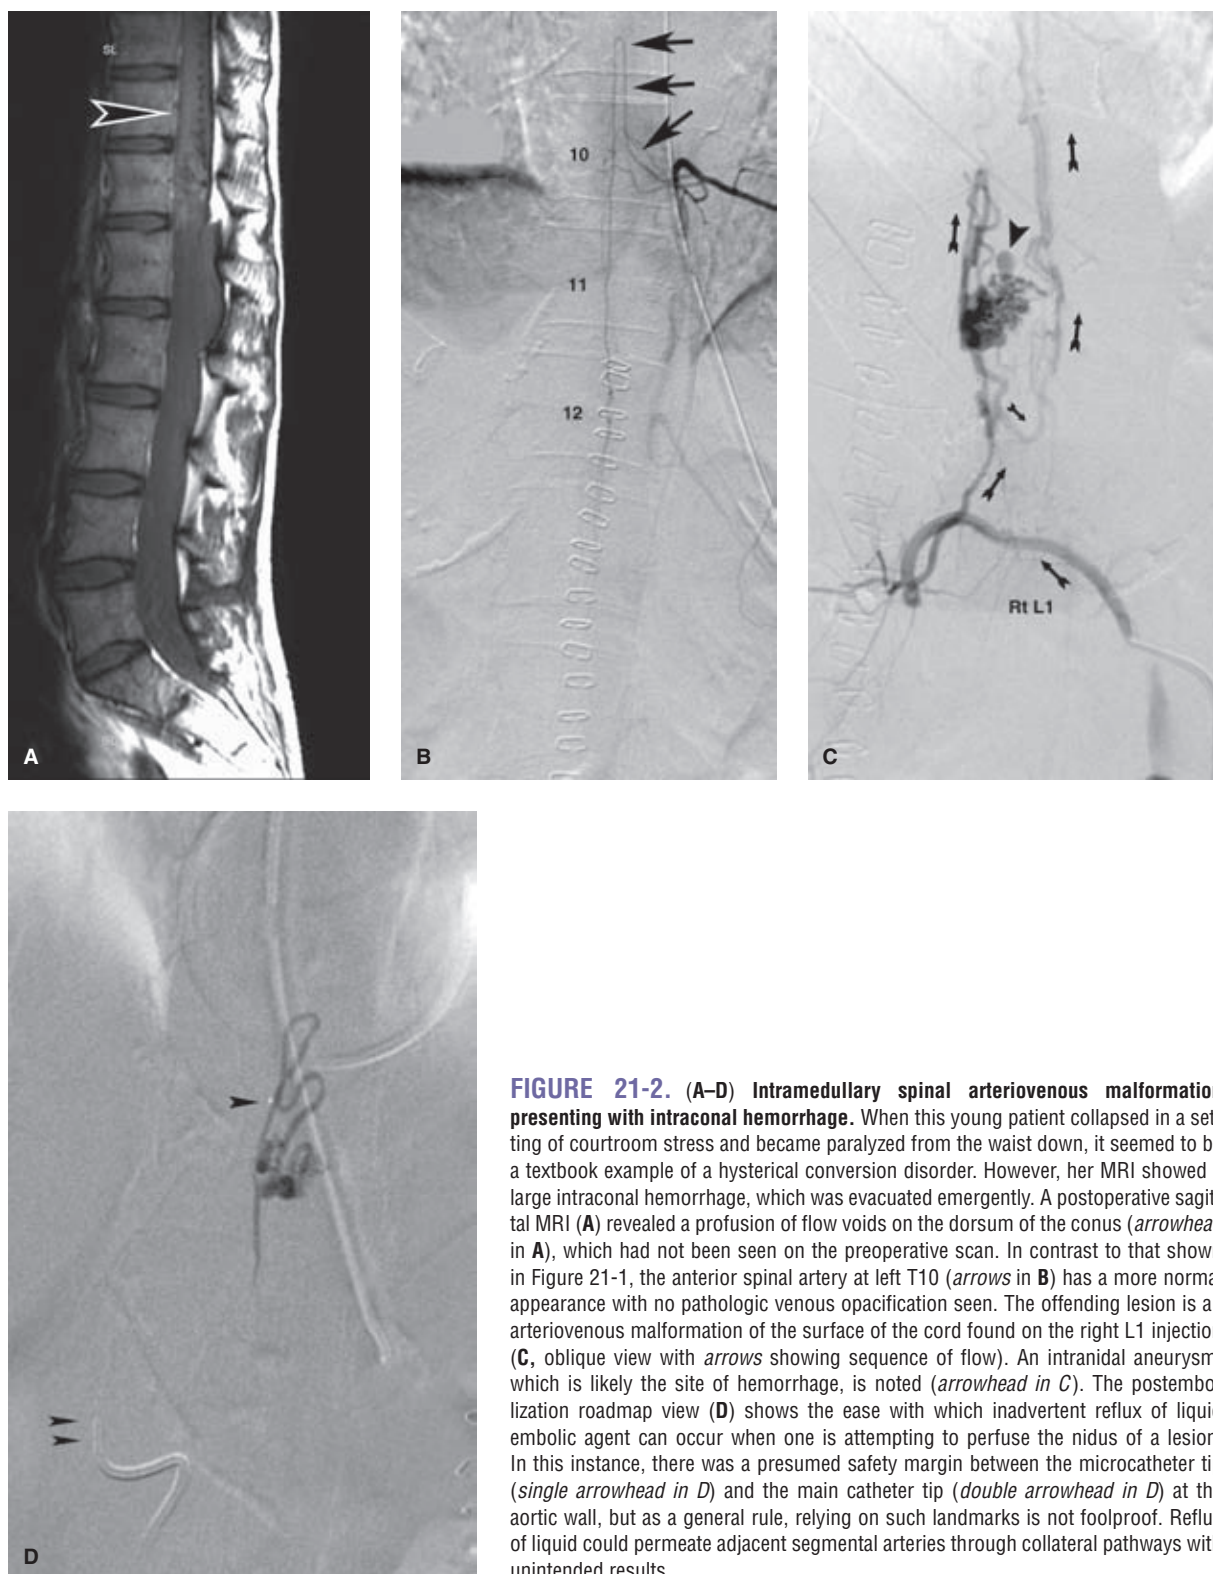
(A–D) Intradural spinal arteriovenous malformation presenting with intracanal hemorrhage. When this young patient collapsed in a setting of courtroom stress and became paralyzed from the waist down, it seemed to be a textbook example of a hysterical conversion disorder. However, her MRI showed a large intraconal hemorrhage, which was evacuated emergently. A postoperative sagittal MRI (A) revealed a profusion of flow voids on the dorsum of the conus (arrowhead in A), which had not been seen on the preoperative scan. In contrast to that shown in Figure 21-1, the anterior spinal artery at left T10 (arrows in B) has a more normal appearance with no pathologic venous opacification seen. The offending lesion is an arteriovenous malformation of the surface of the cord found on the right L1 injection (C, oblique view with arrows showing sequence of flow). An intranidal aneurysm, which is likely the site of hemorrhage, is noted (arrowhead in C). The postembolization roadmap view (D) shows the ease with which inadvertent reflux of liquid embolic agent can occur when one is attempting to perfuse the nidus of a lesion. In this instance, there was a presumed safety margin between the microcatheter tip (single arrowhead in D) and the main catheter tip (double arrowhead in D) at the aortic wall, but as a general rule, relying on such landmarks is not foolproof. Reflux of liquid could permeate adjacent segmental arteries through collateral pathways with unintended results.
